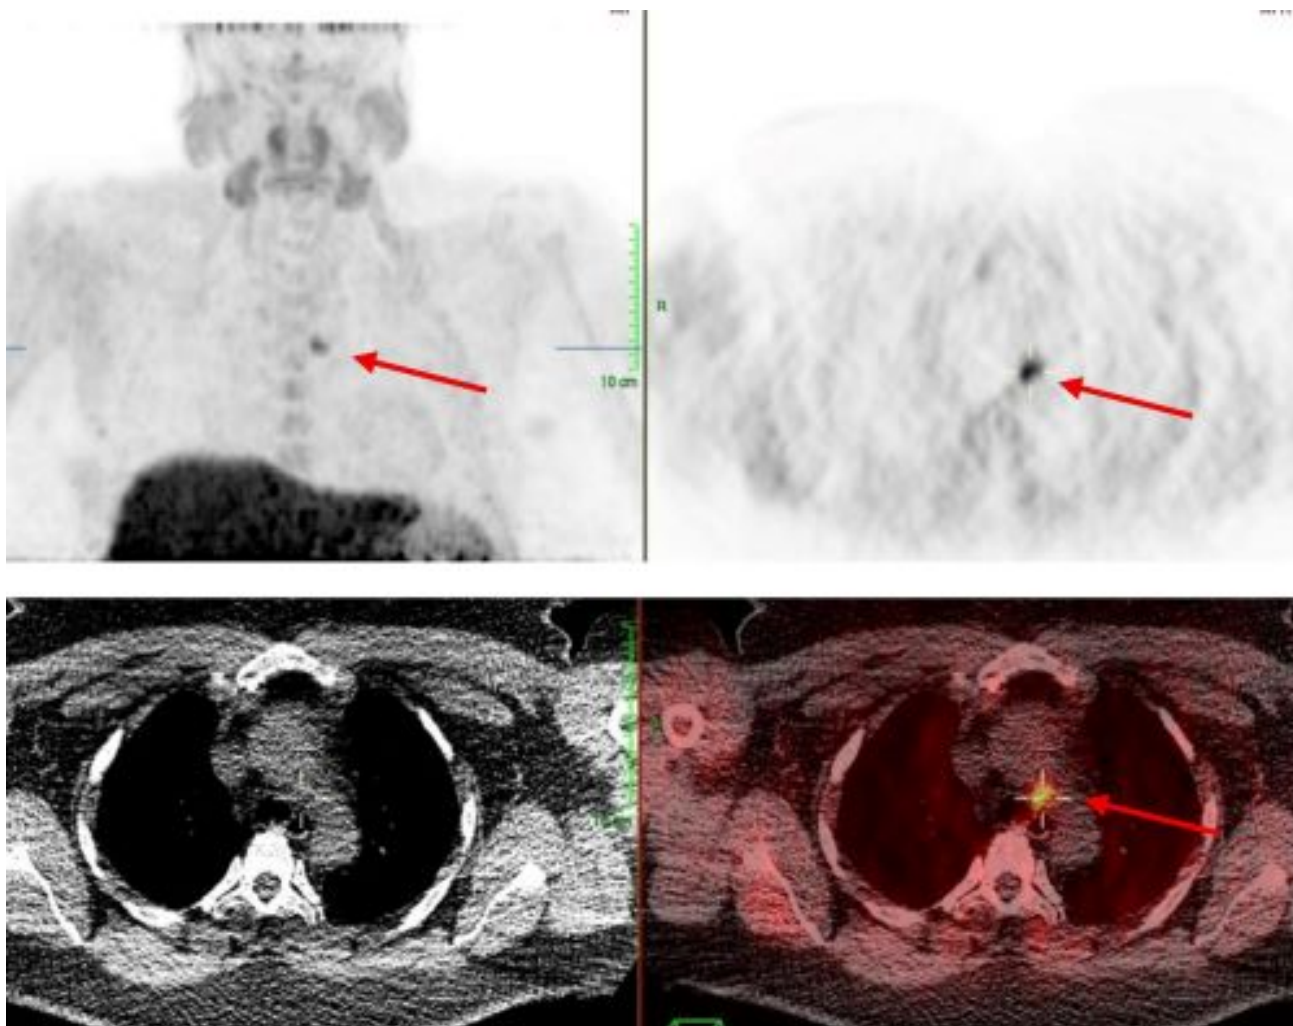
^{18}F -fluorocholine PET CT showing a solitary focus of increased activity in the mediastinum suggestive of ectopic parathyroid adenoma, which is marked with three red arrows. PET, positron emission tomography; CT, computed tomography.
